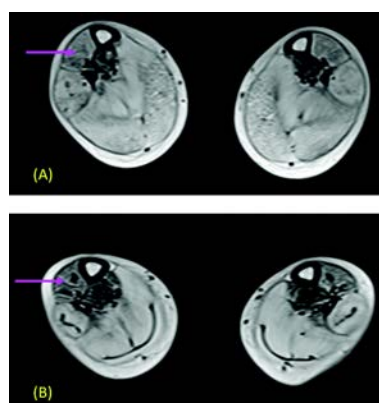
In the figure, a & b show MRI Musculoskeletal images before and after stem cell therapy,*
